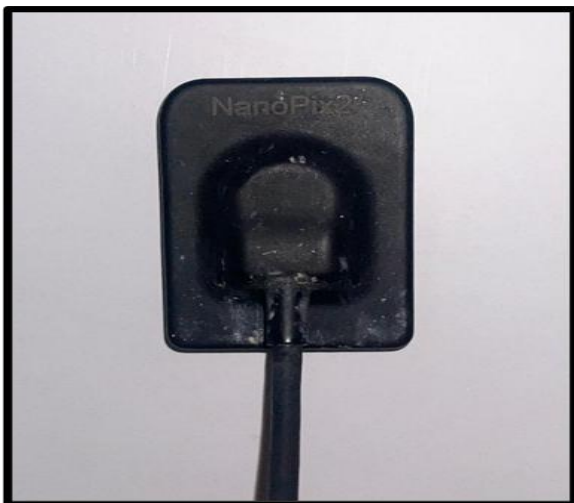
Digital (RVG) X-ray sensor, Orikam, China.
